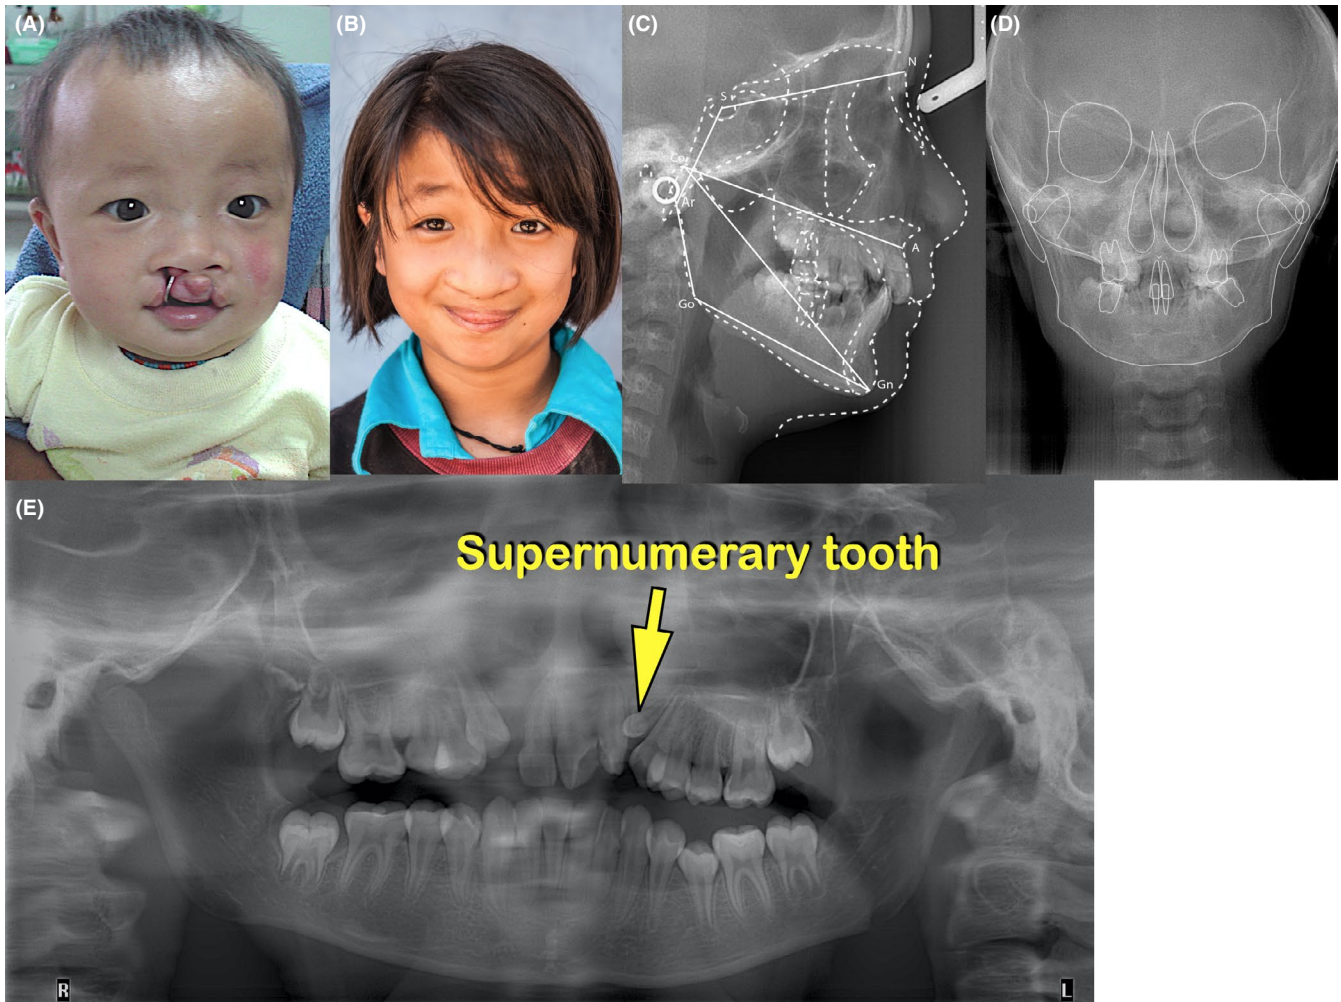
Patient III-1 at ages (A) 8 months. Note bilateral cleft lip and palate with nasopalveolar moulding device. (B) 11 years. (C) Lateral cephalogram at age 11 years show short anterior cranial base length, short posterior cranial base length, short maxillary length, short mandibular length, short mandibular body length and short ramus length. (D) Postero-anterior cephalogram at age 11 years. (E) Panoramic radiograph at age 11 years shows supernumerary tooth in the left cleft area
